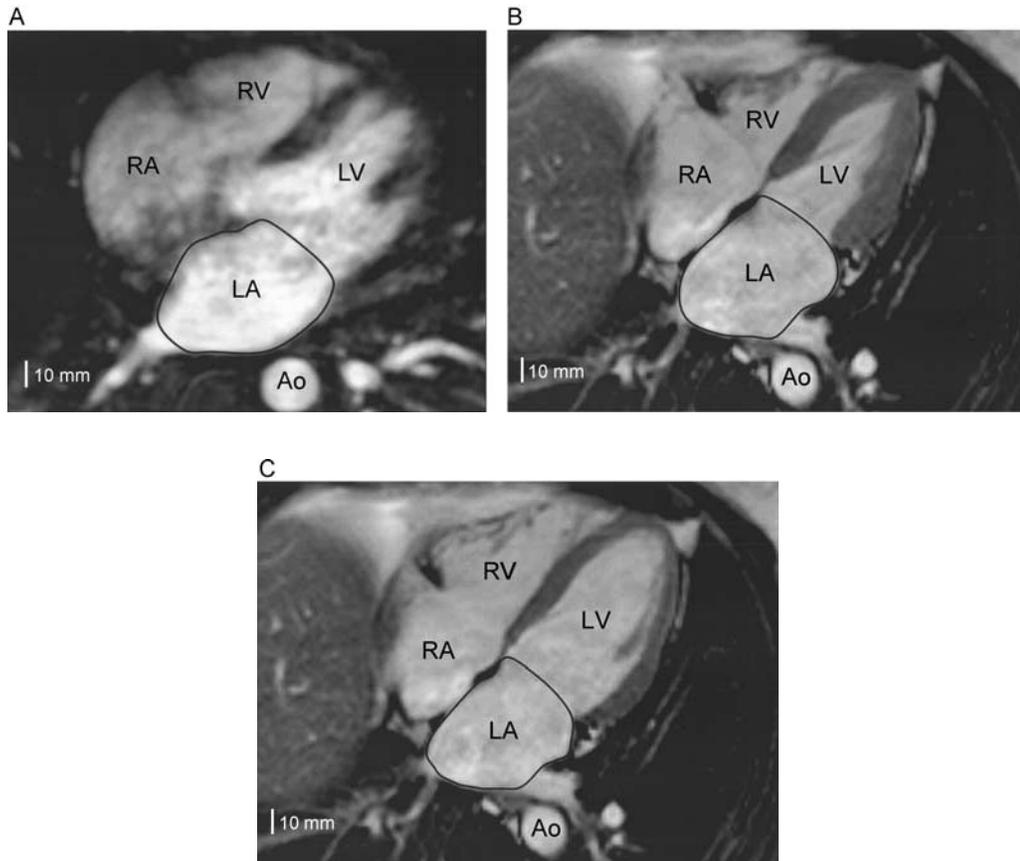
Contrast-enhanced magnetic resonance angiography (CE-MRA) and cine magnetic resonance (MR) images of the left atrium (LA). (A) Shows an axial CE-MRA image of the cardiac chambers. (B) and (C) are four-chamber cine MR images. (B) Shows the LA at its maximum size during the cardiac cycle, which occurs during ventricular systole. (C) Shows the LA at atrial end-diastole. Lines represent the traced area for determination of LA volume. Abbreviations used: Ao=descending aorta, LV=left ventricle, RA=right atrium, RV=right ventricle.
